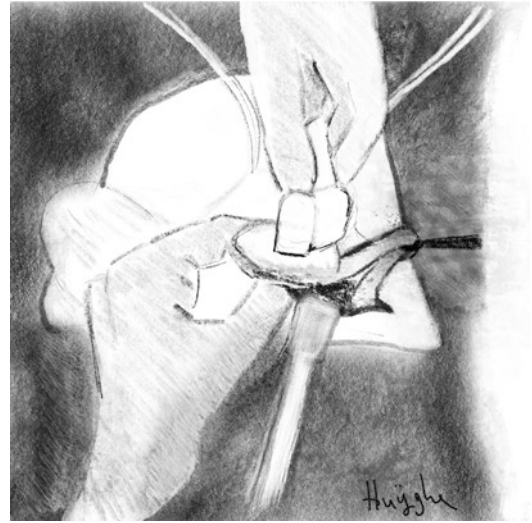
Usage of the intraoperative Doppler ultrasound to localize the tumour and to preserve the intratesticular vessels
